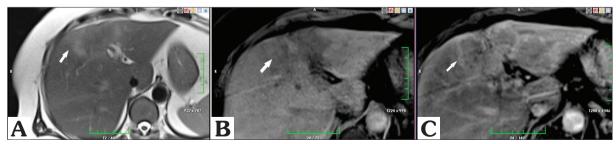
Pretreatment MRI scan. (A) The axial T2-weighted image without fat suppression shows an irregular hyperintense signal (arrow) in the pericapsular region of segment five. (B) The axial T1-weighted image shows an irregular hypointense signal (arrow) in the pericapsular region of segment five. (C) The contrast-enhanced axial T1-weighted image shows a peripheral enhancement pattern (arrow).
